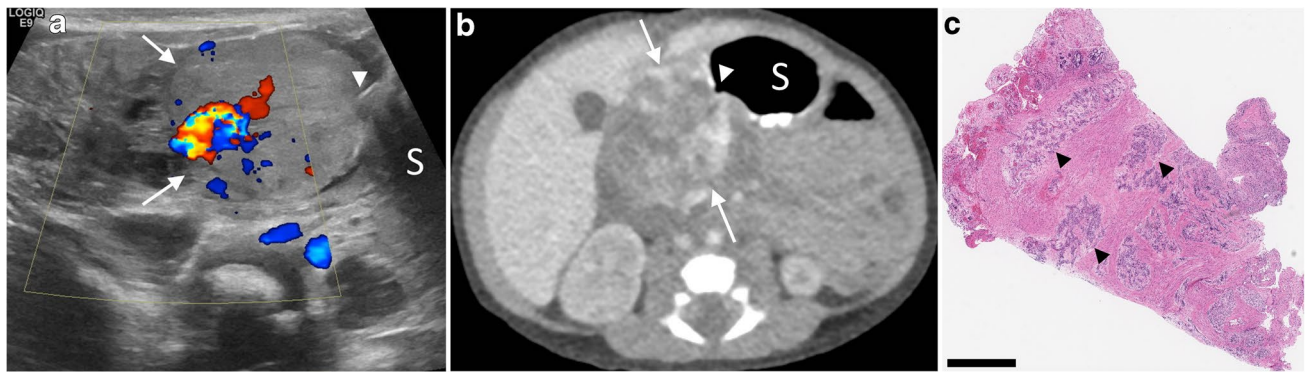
Gastric outlet obstruction caused by congenital duodenal hemangioma in a 5-day-old girl. a, b Transverse color Doppler US (a) and axial contrast-enhanced CT (b) images demonstrate a predominantly solid vascular mass (*arrows*) in the right upper quadrant directly adjacent to the stomach (*S*), with interrupted peripheral enhancement on CT. Air within the lumen of the gastric outlet
